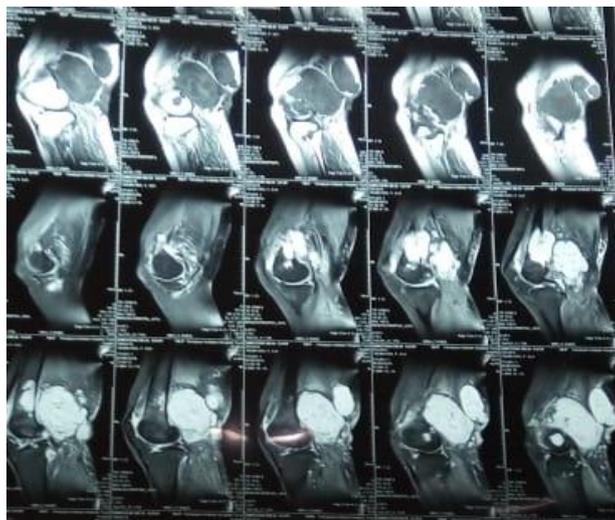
MRI of popliteal fossa suggestive of lobulated mass lesion
